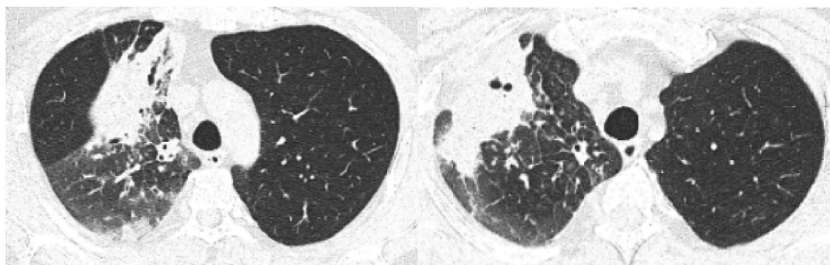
Chest CT examination shows obstructive inflammation and atelectasis in the right upper lobe.
